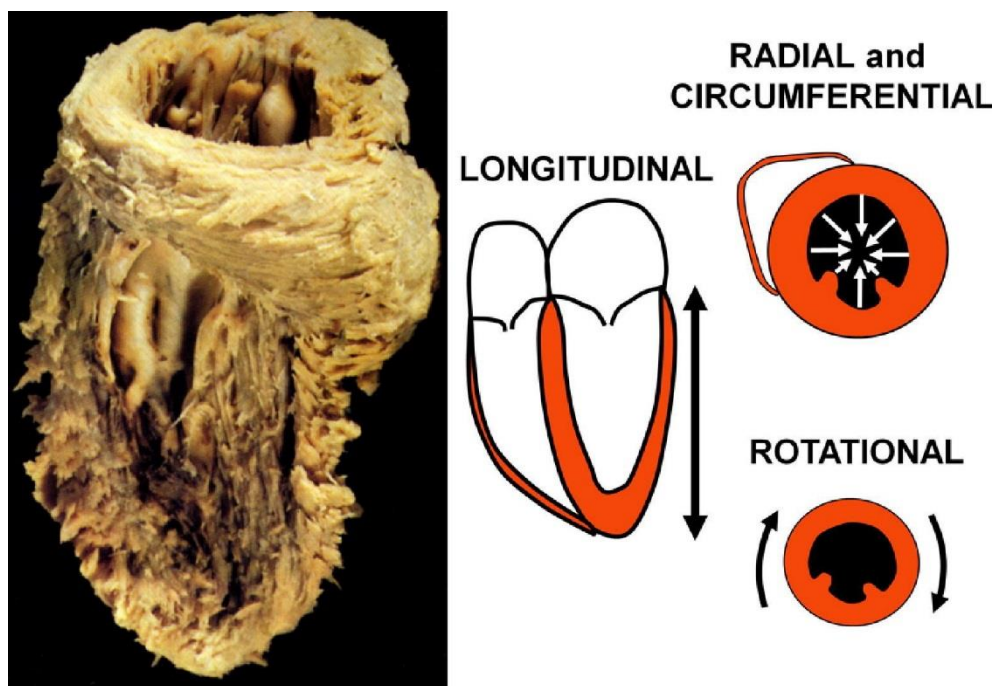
Assessment of 2-dimensional strain by speckle tracking echocardiography in short axis view (above). Orientation of myocardial fibers in the left ventricle and different vectors of myocardial strain (below) Reprinted from Gorcsan et al; JACC 2011; 58 (14): 1401-1413, with permission from Elsevier.
